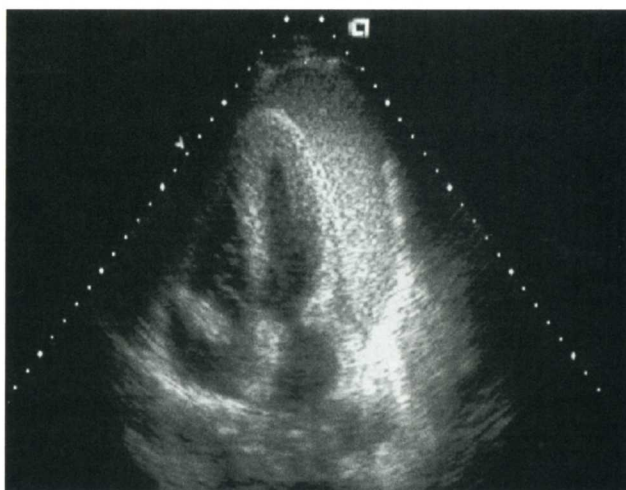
Exudative pericardial effusion (apical four-chamber view).
